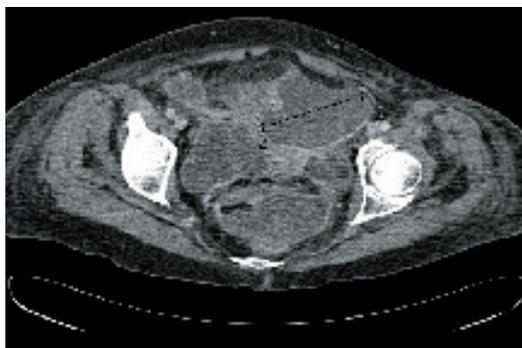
CT Scan showing abscess in the left iliac fossa
